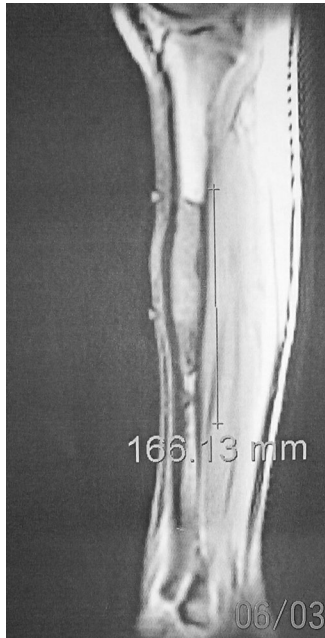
Care of Patient 16 (Table II). Preoperative MRI scan showing tumor.
